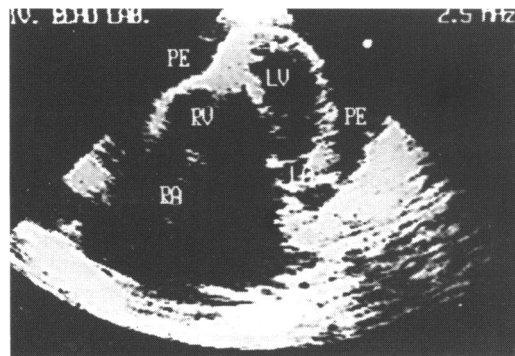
Cross sectional echocardiogram of subcostal long axis view in patient in case 10 showing dilated right atrium (RA), right atrial thrombus (TH), right ventricular obliteration, normal left ventricular (LV) endocardial surface, and massive pericardial effusion (PE) (AO, aorta).
